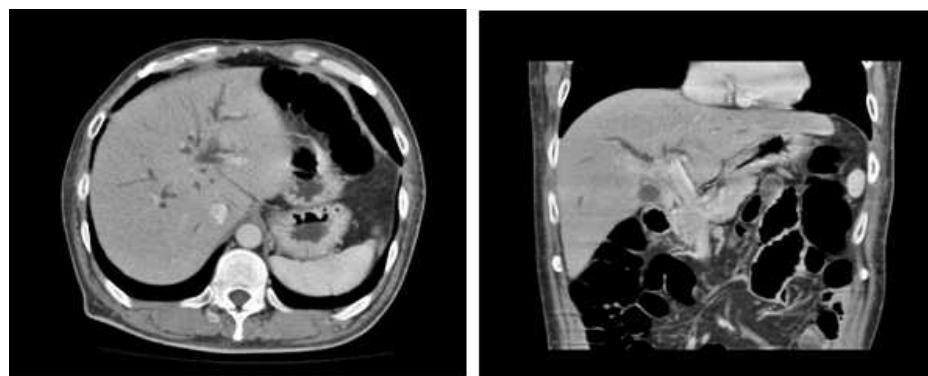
Abdominal computed tomography image of the patient before steroid therapy. (left) Transverse section shows the dilation of the intrahepatic bile duct. (right) Coronal section shows wall thickening and imaging effect from the middle to the hilar bile duct.
